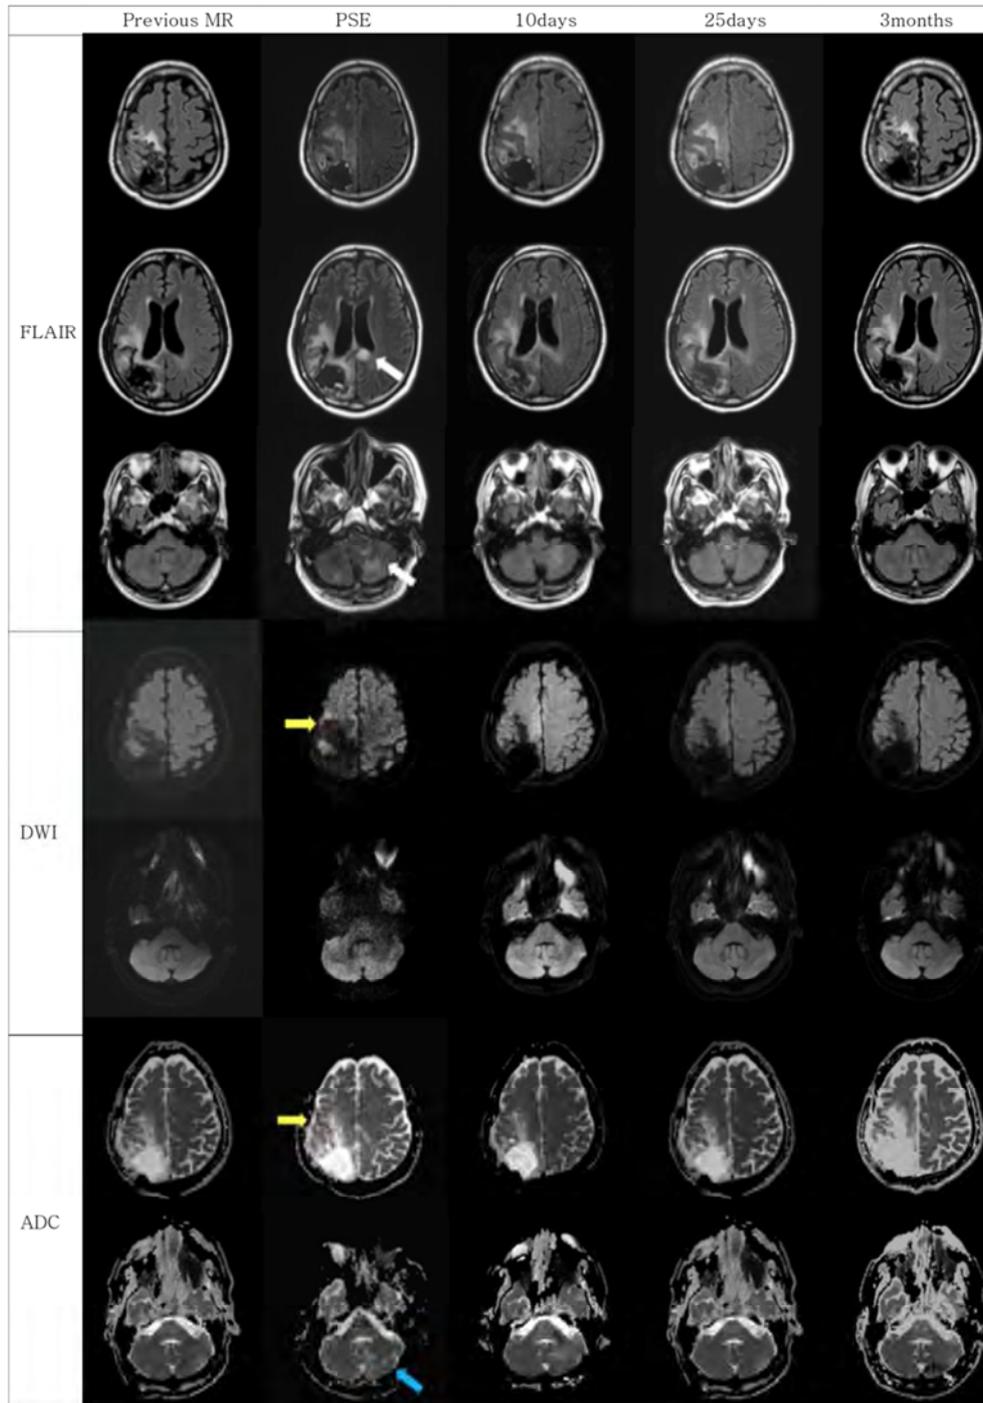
Serially followed FLAIR, diffusion-weighted MRI (DWI) and apparent diffusion coefficient maps (ADC) from patient before, during and after partial status epilepticus (PSE). During PSE, FLAIR MR images show newly developed high signal in the right frontal, parieto-occipital lobe, corpus callosum and left cerebellum (white arrows). DWI shows high signal in the right frontal lobe and low ADC in the corresponding area (yellow arrows). ADC map shows high ADC in the corpus callosum, left occipital lobe and left cerebellum (blue arrow). Follow-up MRI performed 10 days, 25 days and 3 months later showed that previous high signal in the cerebellum and corpus callosum disappeared in FLAIR MRI. High signal on DWI and decreased ADC on ADC map in the right frontal region disappeared gradually.
